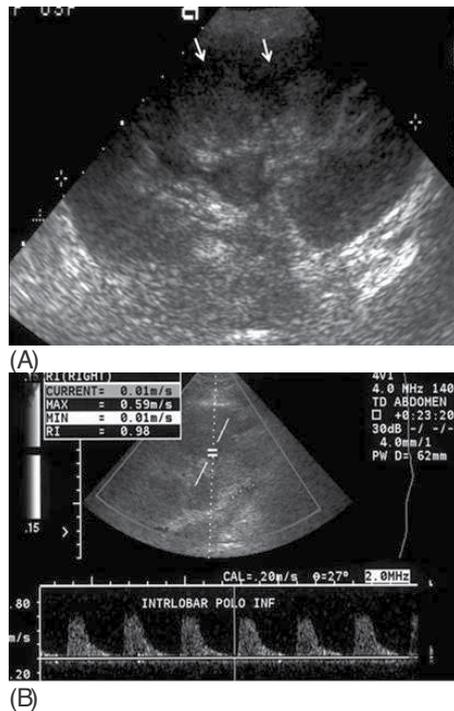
(A) Acute rejection, longitudinal scan. The cortex is swollen, extending into the renal sinus and compressing the fat. Medullary pyramids are prominent (arrows), indicative of an increase in cortical echogenicity. (B) Spectral Doppler shows a RI $>0,90$ highly suggestive of AR.
